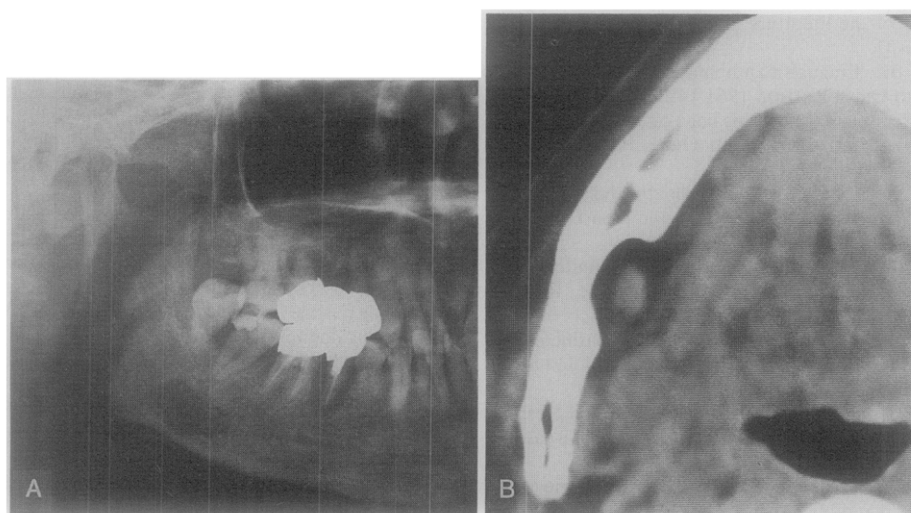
A, Panoramic radiograph of case 5 reveals elliptical radiolucency on right side of mandible; density is higher than that of case 14 shown in Fig. 4. B, Axial CT image shows small soft tissue density mass in concavity. Bottom of concavity does not reach buccal plate.
